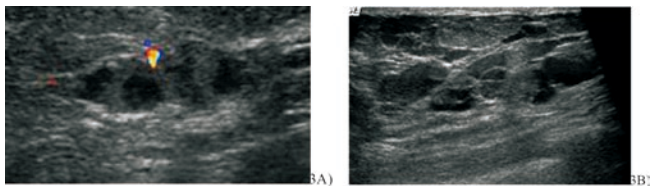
Ultrasonography revealed numerous intraductal lesions with dimation subcentimeter at the site of mammographic findings.
